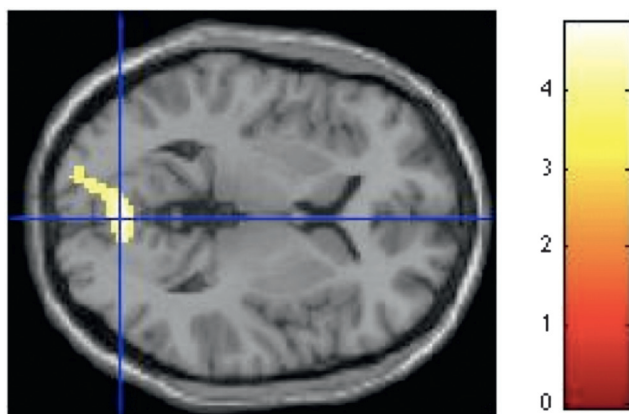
Curvilinear spaces activate the lingual gyrus and calcarine in approach-avoidance decisions. SPM rendered into standard stereotactic space and superimposed on to transverse MRI in standard space. Bar represents magnitude of t -score.[NOTE: Figure can be viewed in color in the PDF version of this volume on the National Academies Press website, www.nap.edu/catalog.php?record_id18573.]
